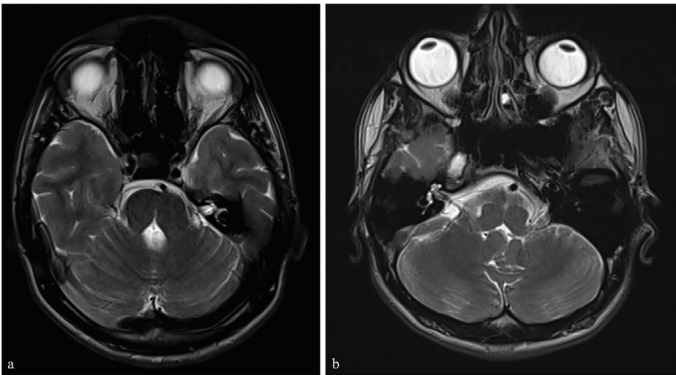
Axial T2-weighted cranial magnetic resonance imaging demonstrates a fissure extending from the posterior midsagittal aspects of the pons (a) and the medulla oblongata (b) to the floor of the fourth ventricle
